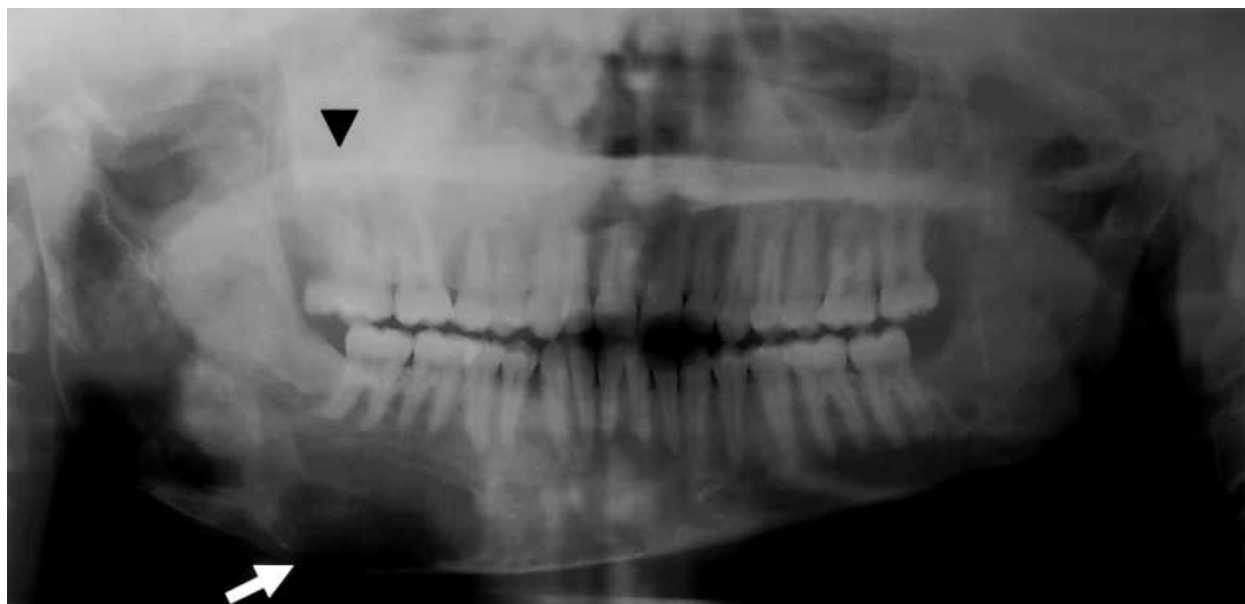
Radiolucent pattern. Fifteen-year-old female patient with fibrous dysplasia (FD) of right maxilla and mandible. Panoramic radiograph shows jaw asymmetry caused by FD expansion of right maxilla and mandible compared with unaffected left side. Mandibular FD is radiolucent (solid white arrow) and extends from the right condyle to the symphysis while maxillary FD is radiopaque (black triangle) and completely masks the maxillary sinus outline. This patient also presented with multiple dysregulated endocrine/metabolic functions that included precocious puberty, hyperthyroidism, renal phosphate wasting and hypovitamin D₃ associated with secondary hyperparathyroidism
